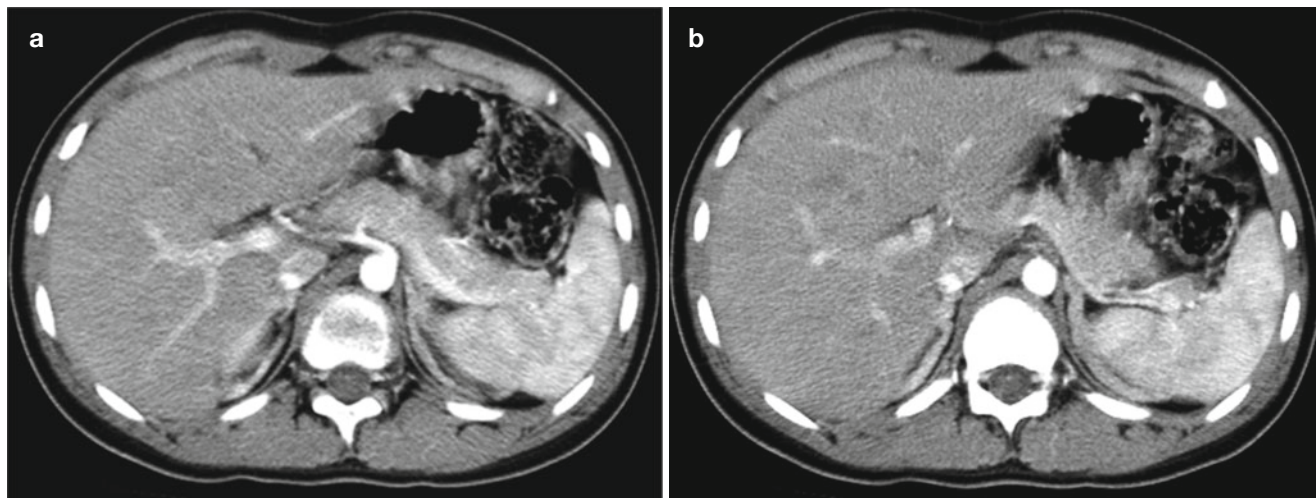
Peripheral precocious puberty in 15-year-old girl with massive vaginal bleeding. (a) and (b) Contrast-enhanced axial CT scans show diffuse enlarged both adrenal glands, suggesting adrenal hyperplasia
